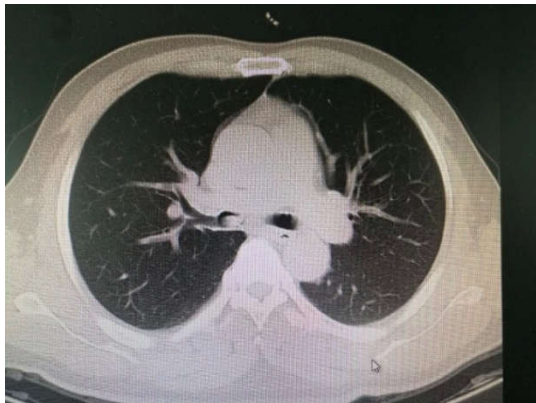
Chest CT showed a long strip foreign body shadow in the right low bronchus
